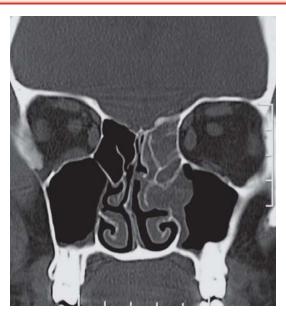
Plain CT PNS coronal cut at osteomeatal complex showing left ethmoid polyps
